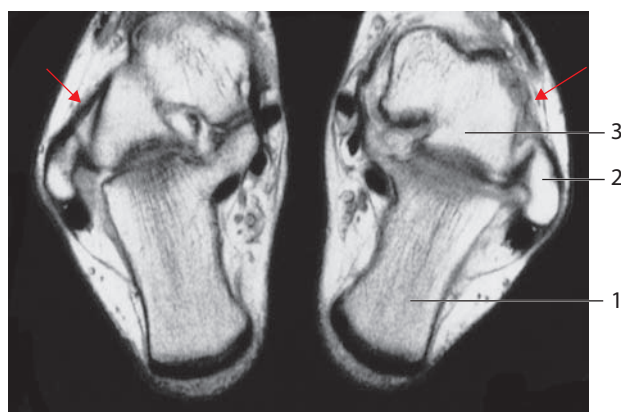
Magnetic resonance imaging is seldom needed in the acute phase, but will give a good evaluation of both the anatomy and the extent of the injury. On the picture to the left the arrow indicates a normal ATFL ligament, and on the picture to the right the arrow indicates a torn ATFL ligament. 1: Calcaneus (heel bone); 2: fibula; 3: talus.
